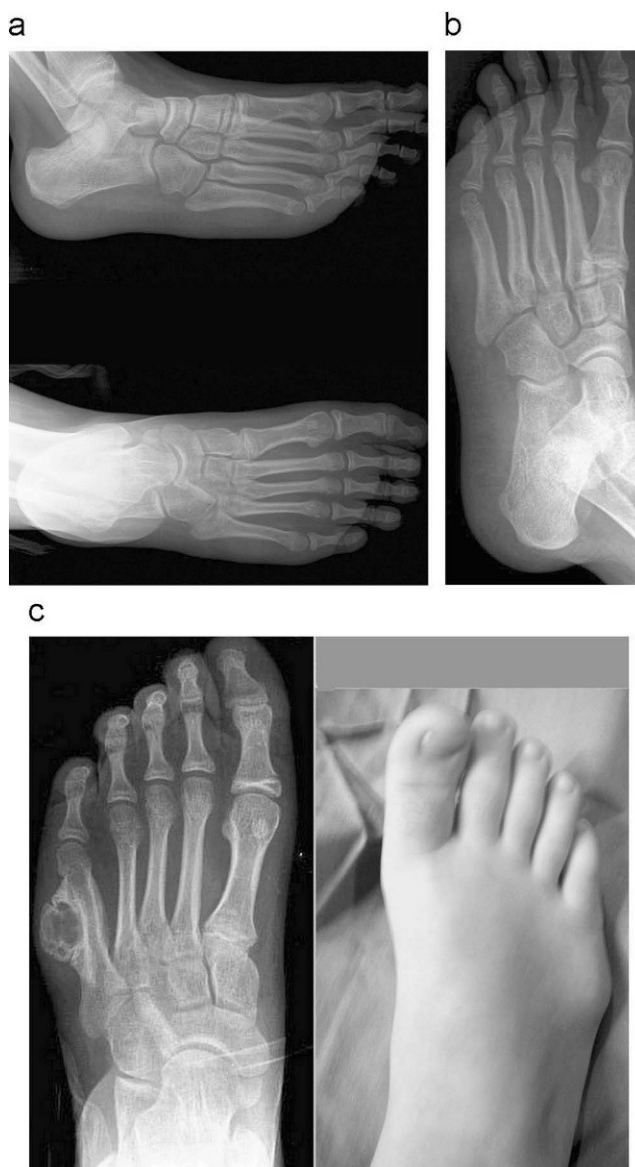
a) Initial X-rays in which no lesion is detected. b) 10 days later, periosteal reaction in the external cortex of the fifth metatarsal. c) At 2 months with swelling on the external cortex of the fifth metatarsal and medial periosteal separation.
